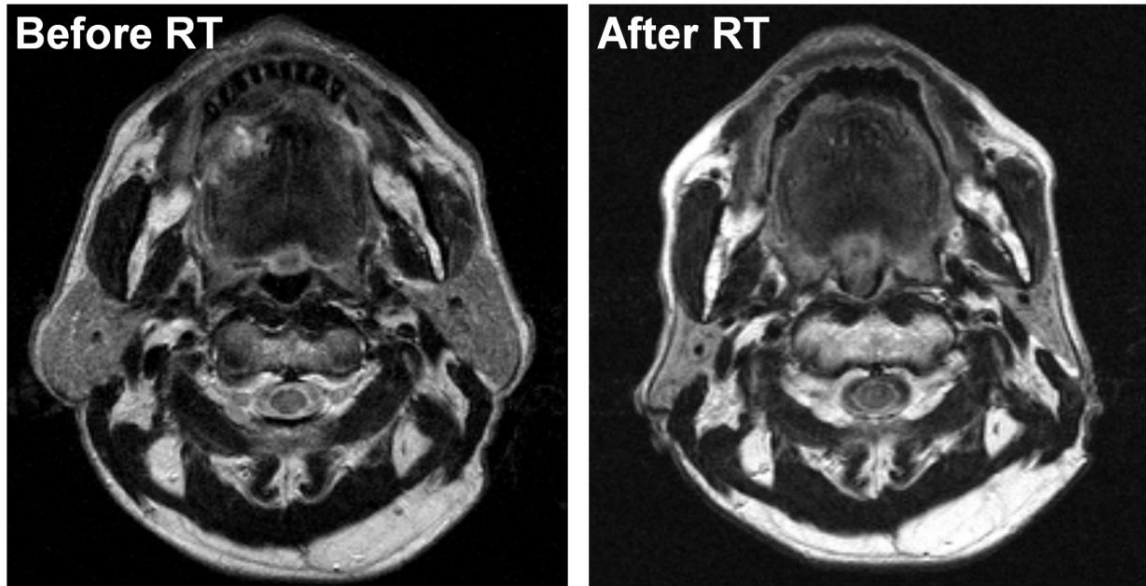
This 63-year-old man with squamous cell carcinoma of the floor of the mouth (T3N0) was treated with preoperative CRT. T2-weighted (3700/92) MR images obtained before and after CRT demonstrated morphological changes of the parotid glands. After 30-Gy irradiation, the parotid volume was decreased from 90 cm³ to 49 cm³; the changes manifested a post-CRT:pre-CRT parotid volume ratio of 54%.
